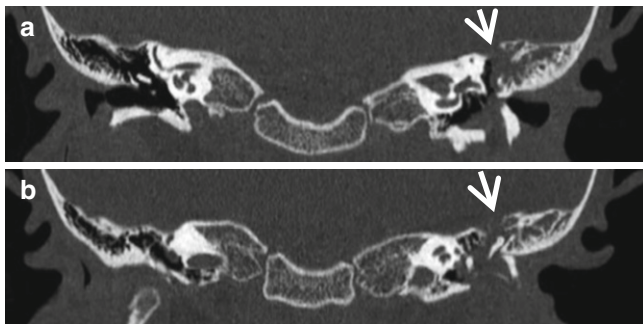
Transverse temporal bone fracture in a 7-year-old boy. (a, b) Thin-section temporal bone CT with coronal reconstruction shows a cortical bone breakdown (*arrows* in a and b) through the left middle ear cavity. Note ossicular disruption
